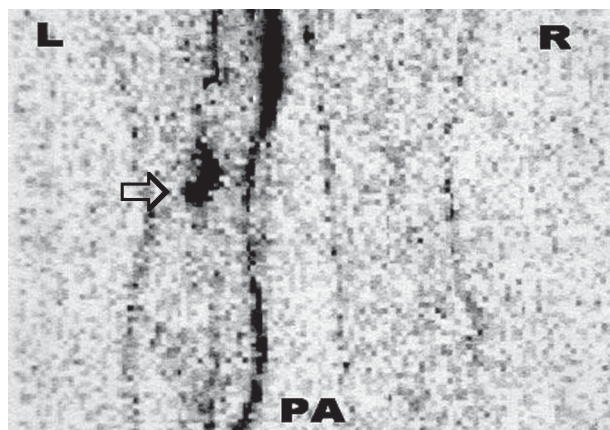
Lymphoscintigraphy of the melanoma of the left calf. Lymphatic drainage passes to the left groin where one SLN was found, but in the left popliteal fossa two in-transit nodes (circle) were seen, which also represented SLNs in this case; L- left leg, R- right leg, PA - posterior view.
